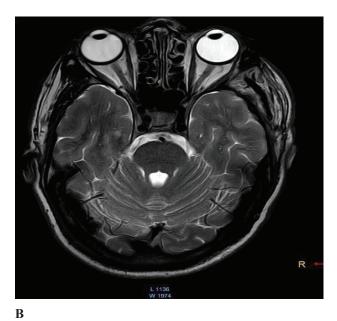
3-month post-operative MRI orbit a) contrast T1WI b) T2WI
